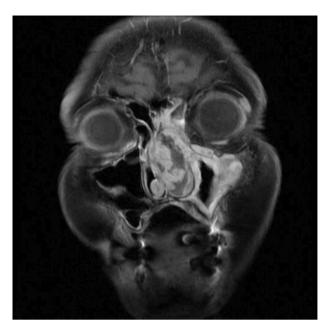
Sinus T1-weighted gadolinium-enhanced MRI, coronal slice.
